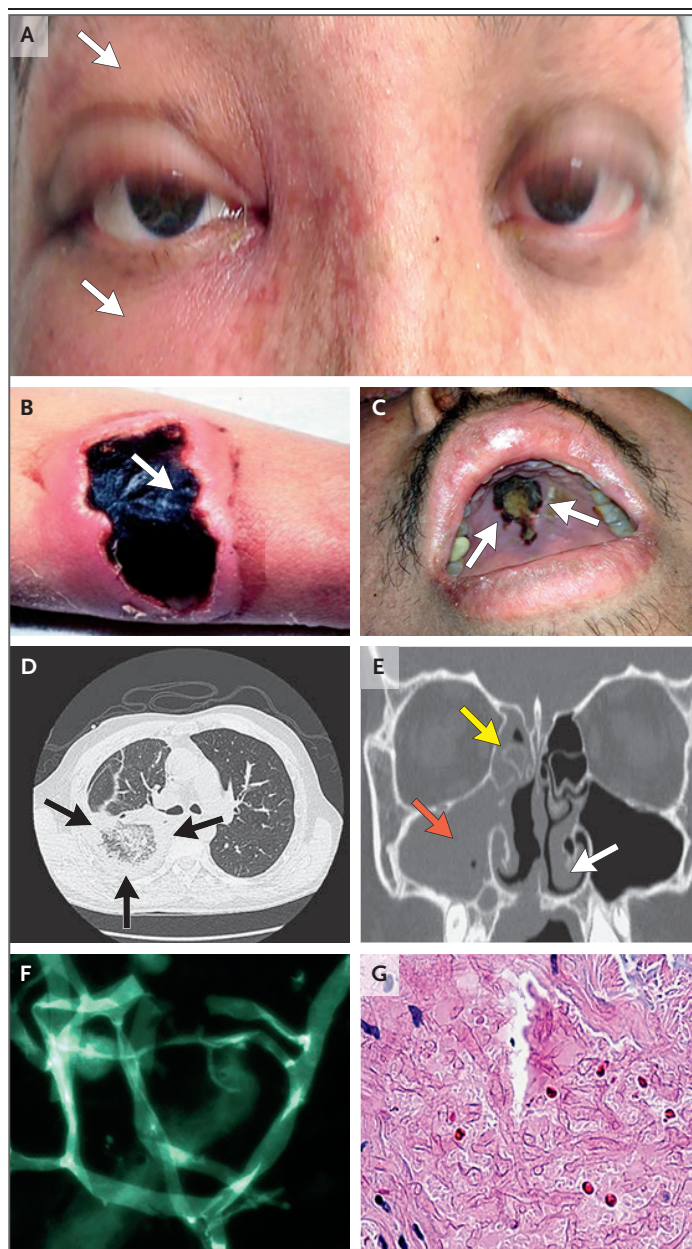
Direct Examination and CT Imaging in Mucormycosis.
